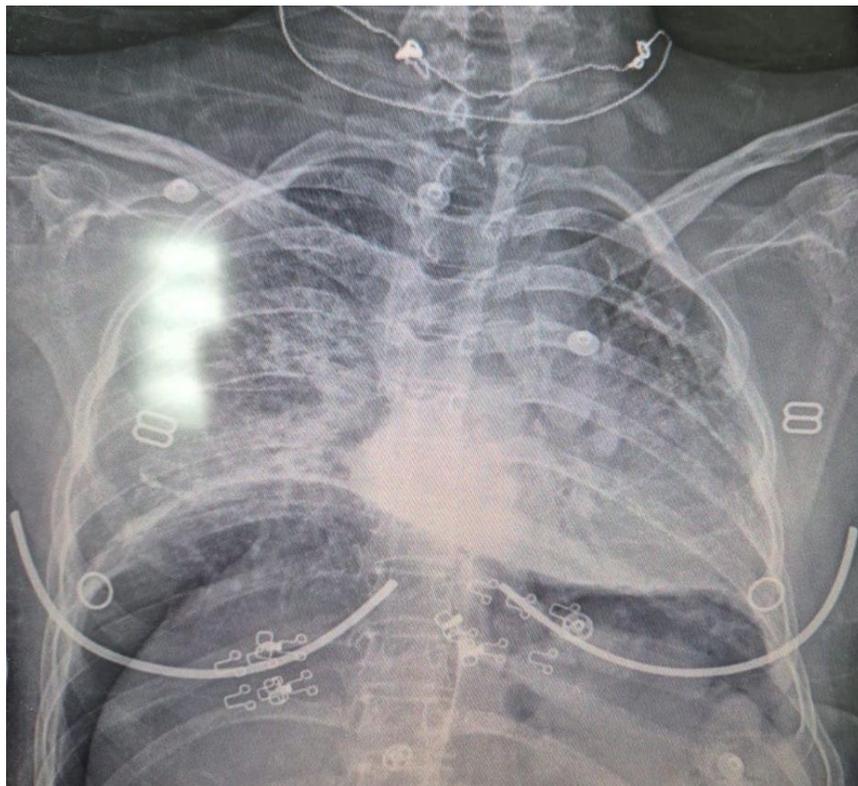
Chest radiograph demonstrating bilateral subdiaphragmatic free air consistent with massive pneumoperitoneum.
